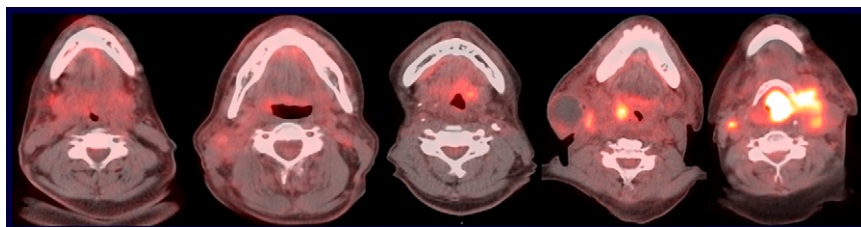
Developed Hopkins Criteria for interpretation of therapy response. Example images (left to right): score 1—FDG uptake at the primary site and nodes less than background blood pool (internal jugular vein, IJV); score 2—focal ^{18}F -FDG uptake at the primary site and nodes greater than blood pool (IJV) but less than liver; score 3—diffuse ^{18}F -FDG uptake at the primary site or nodes
